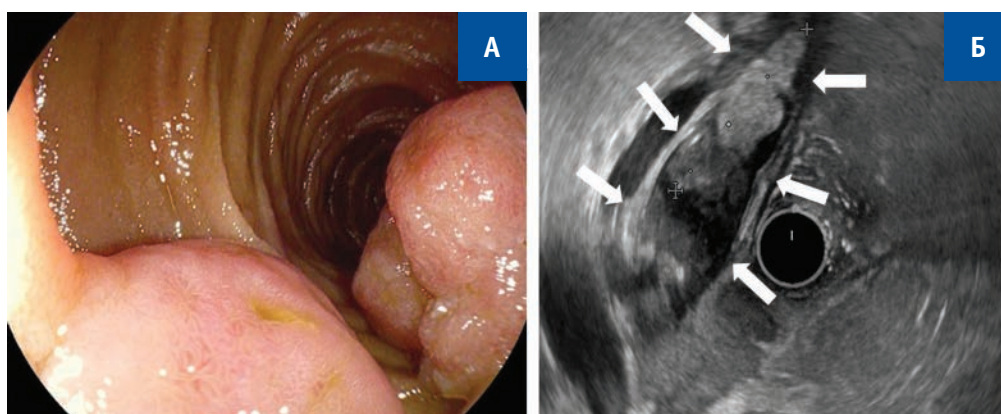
A — duodenoscopy: MDP adenoma with suprapapillary extension to the intestinal wall, a large duodenal adenoma is also visualized distal from MDP; B — endosonography: an extended intraductal component of the adenoma in the lumen of the CBD (arrows)
